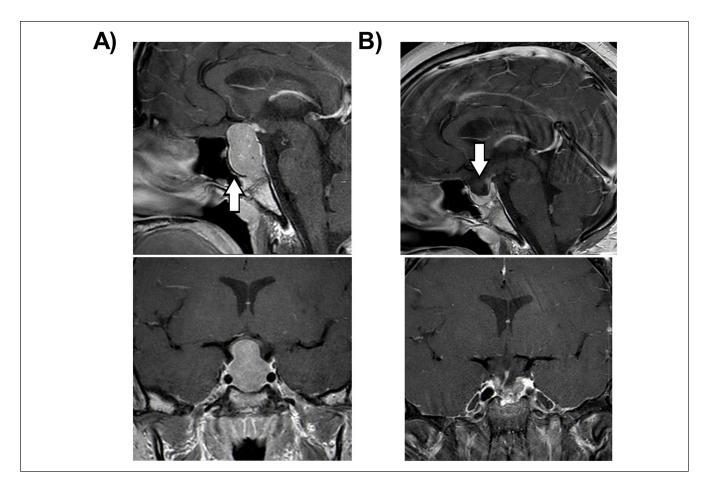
(A) Magnetic resonance imaging (MRI) sagittal and coronal post-contrast TIW images show a large homogenous hypoenhancing intrasellar mass with suprasellar extension and sellar floor erosion (white arrow). Notice mass effect on optic chiasm and third ventricle floor. (B) Posttreatment MRI sagittal and coronal post-contrast TIW images show concave superior margin of the pituitary gland with slight prolapse of the optic chiasm into the enlarged sella (white arrow). The infundibulum is deviated to the right and there is complete imaging resolution of the pituitary tumor.
